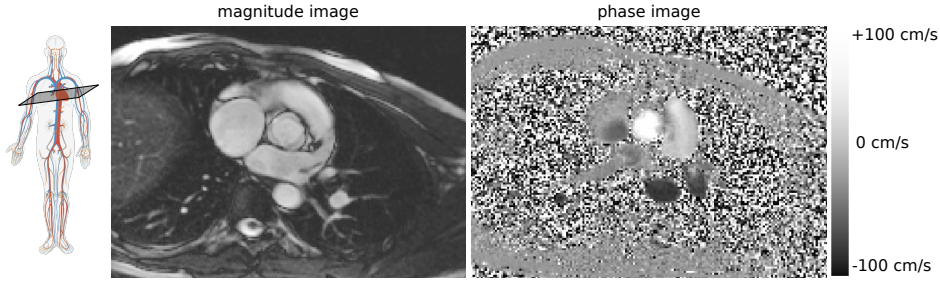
Magnitude (from cine bSSFP sequence) and phase (from PC MRI sequence) image data. The 2D slice was prescribed such that it cuts through the base of the heart and the aortic valve. Image acquisition was triggered to peak systole to capture the open aortic valve.
